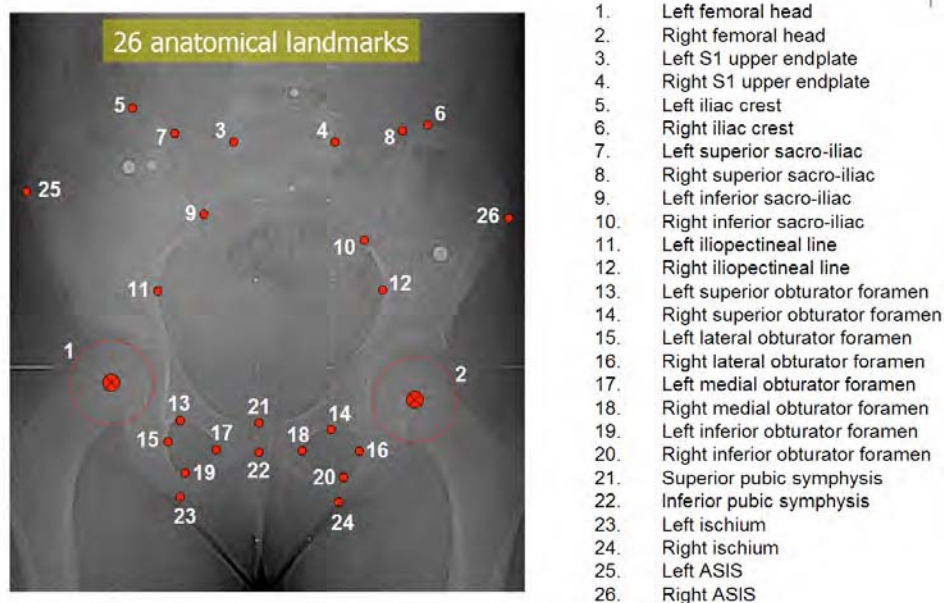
Anatomical landmarks digitized on the PA radiograph
